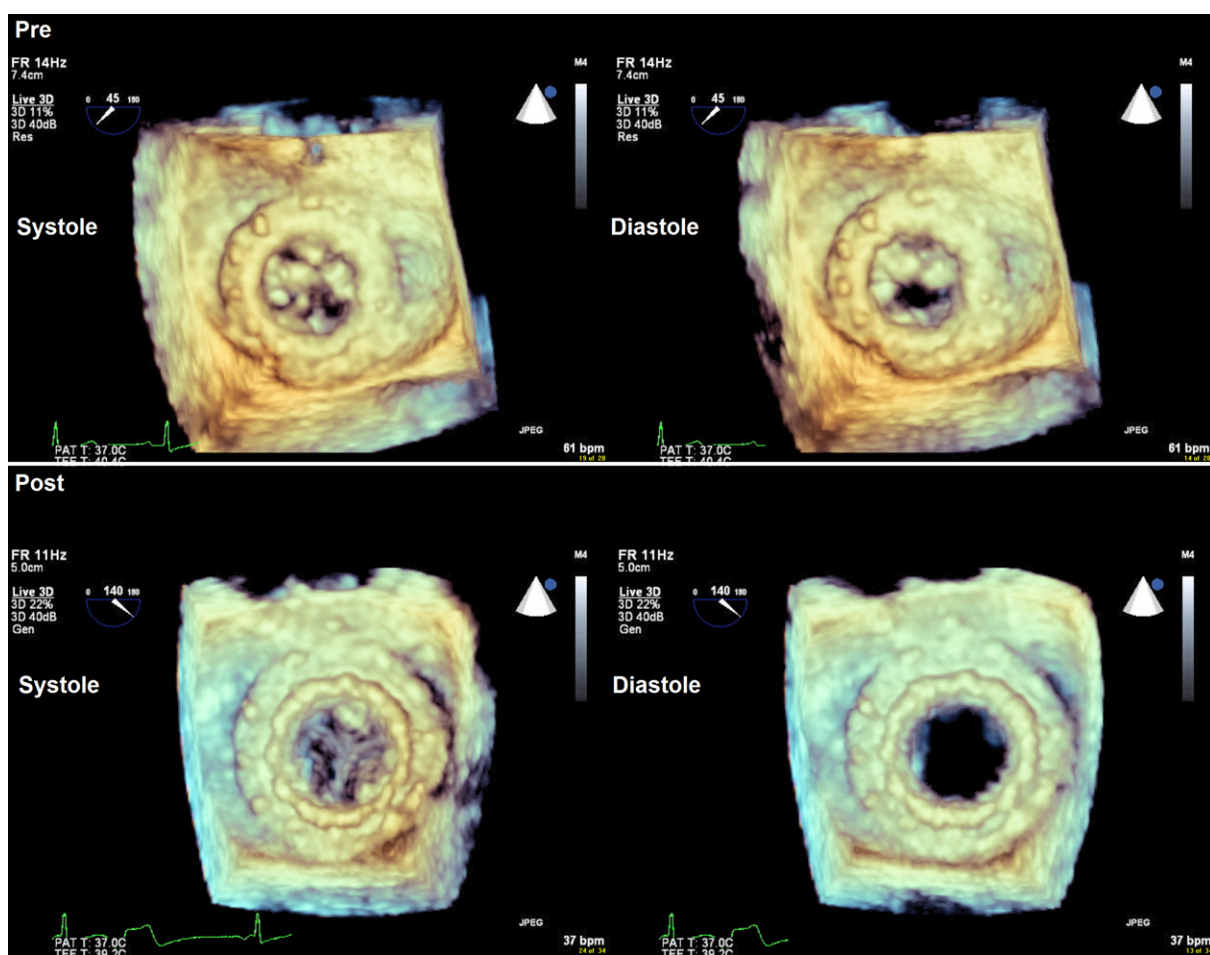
3D Transesophageal Echocardiogram Pre- and Post-Transapical Mitral Valve-in-Valve Implantation
